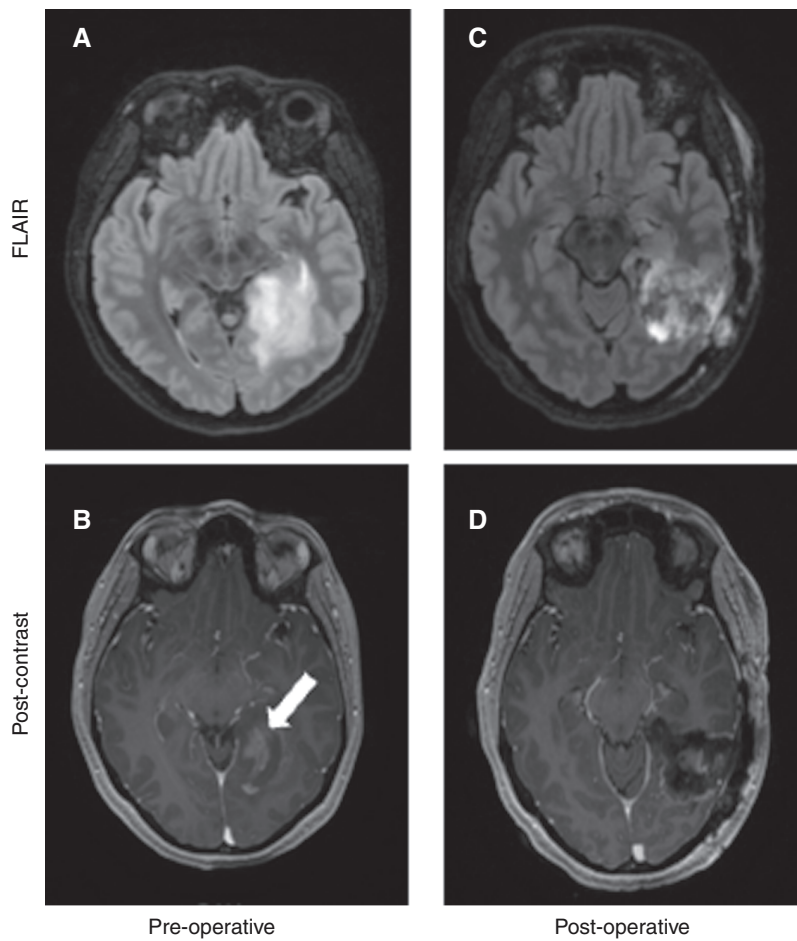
Radiologic example of an enhancing, astrocytoma, mIDH, grade 2. Preoperative FLAIR (A) and postcontrast T1 (B) image demonstrating an area of focal enhancement (arrow) from a 35-year-old female who presented with progressive headaches. She underwent gross total resection of the FLAIR (C) and enhancement (D) and pathology confirming astrocytoma, mIDH, grade 2 with no evidence of high-grade features such as conspicuous mitoses (Ki-67 2%), vascular proliferation, or necrosis. Targeted next-generation sequencing revealed mutations in *ATRX* and *TP53*.
